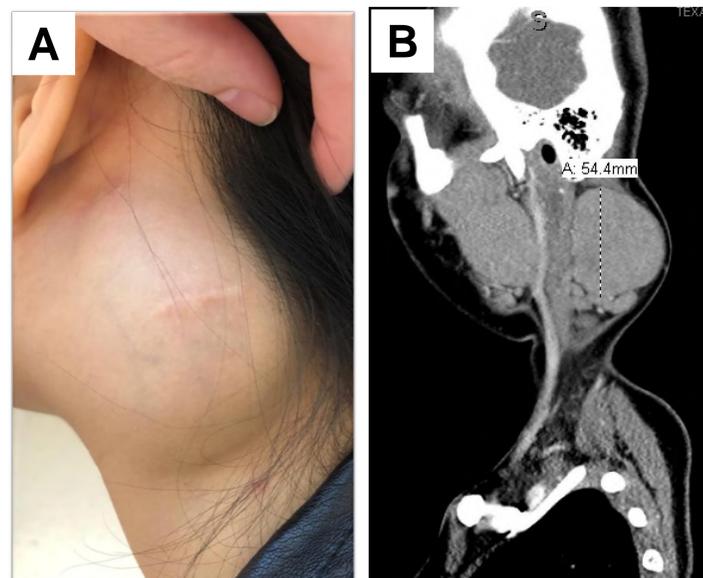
Left neck mass. A: Photograph of left-sided neck mass. B: CT scan showing large well-delineated, non-calcified homogenous, non-necrotic nodal mass.
